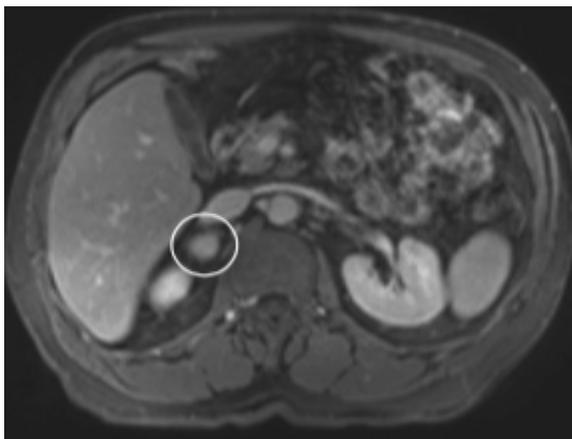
MRI scan of the abdomen showing right adrenal mass (50 mm x 27 mm).
